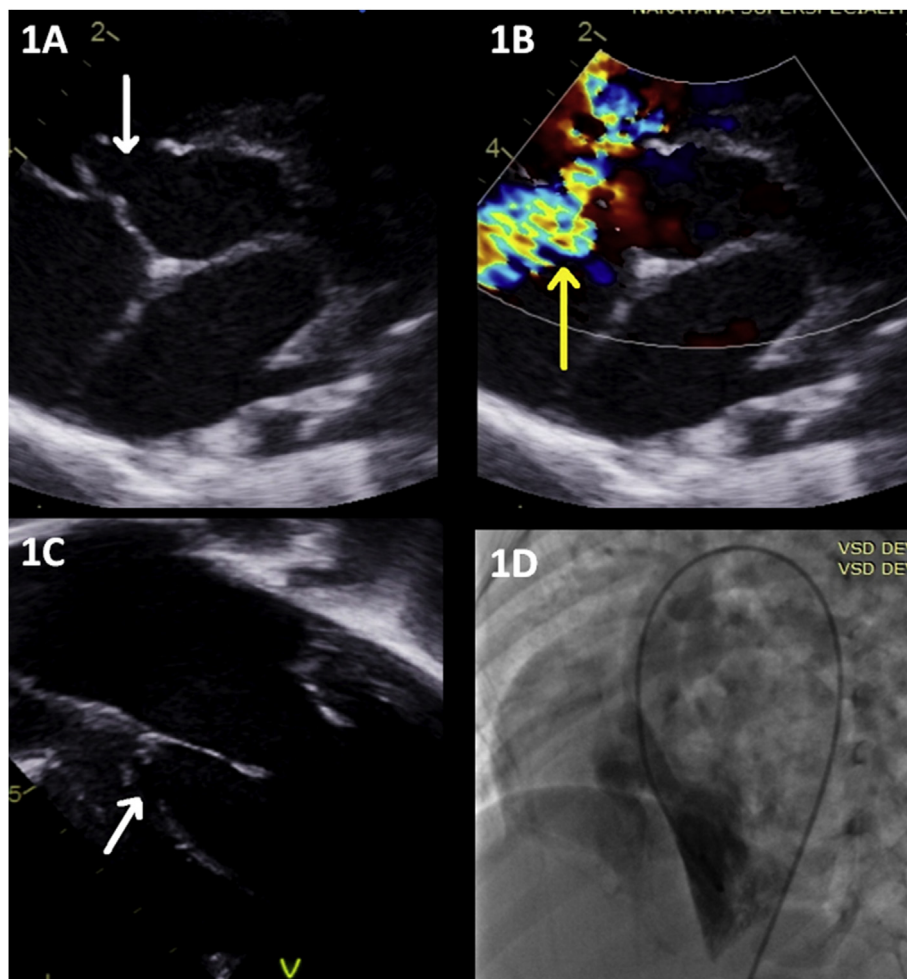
Profiling the VSD- 2D echocardiography Parasternal short axis view showing large perimembranous VSD (White arrow) restricted by septal leaflet of tricuspid valve (1A), Colour Doppler echocardiography showing large perimembranous VSD with left to right shunt with VSD jet directed towards right atrium as Tricuspid regurgitation (Yellow arrow) (1B), 2D echocardiography Apical 4 chamber view showing moderate sized perimembranous VSD (White arrow) (1C), Left ventriculogram (LV) in left anterior oblique view with cranial tilted projection showing moderate sized perimembranous VSD (1D).
